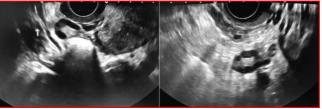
Trans vaginal Ultrasound showing PCO.
